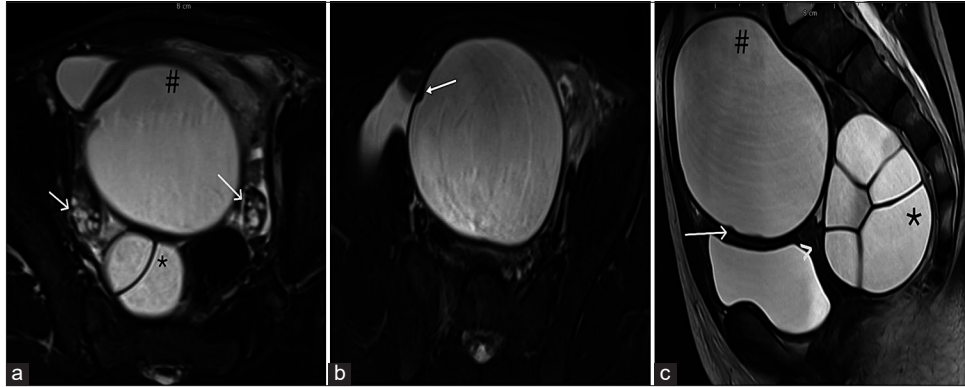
Magnetic resonance imaging showing omental and deep pelvic hydatid cysts. (a) Axial T2-weighted short tau inversion recovery (STIR) image demonstrates a well-defined omental cyst (#) and a multiloculated retrorectal cyst (*) with both ovaries (white arrows) seen separately from the lesions, confirming an extra-ovarian origin. (b) Axial T2-weighted STIR image shows the omental cyst with focal wall nodularity (white arrow). (c) Sagittal T2-weighted STIR image demonstrates the omental cyst (#) with wall nodularity (white arrow) and the multiloculated rectovesical cyst (*); note the compressed uterus (white arrowhead) displaced between the rectovesical cyst and urinary bladder.
